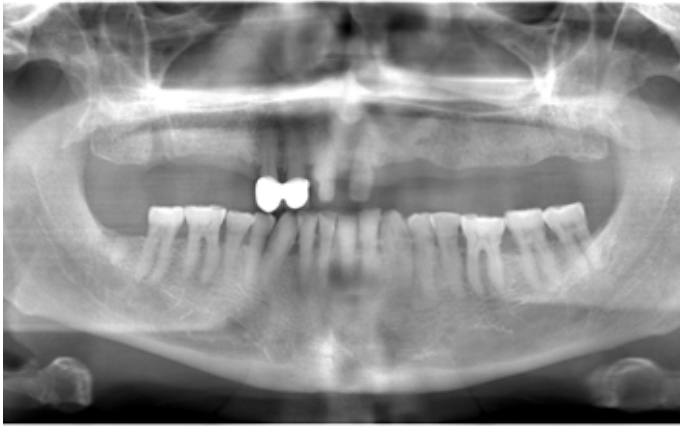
Orthopantomogram (OPTG) was advised that revealed decreased to the alveolar bone
